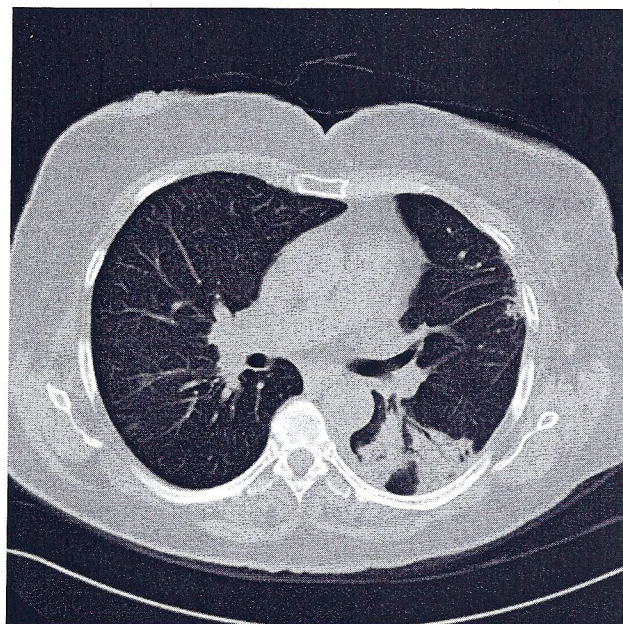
Chest CT scan of a 46-year-old woman who had radiation for a left breast carcinoma. There is subpleural peripheral fibrosis in the left upper lung secondary to the radiation, and BOOP as a right mid-lung ground-glass opacity with air bronchograms. The BOOP resolved rapidly with prednisone therapy.
